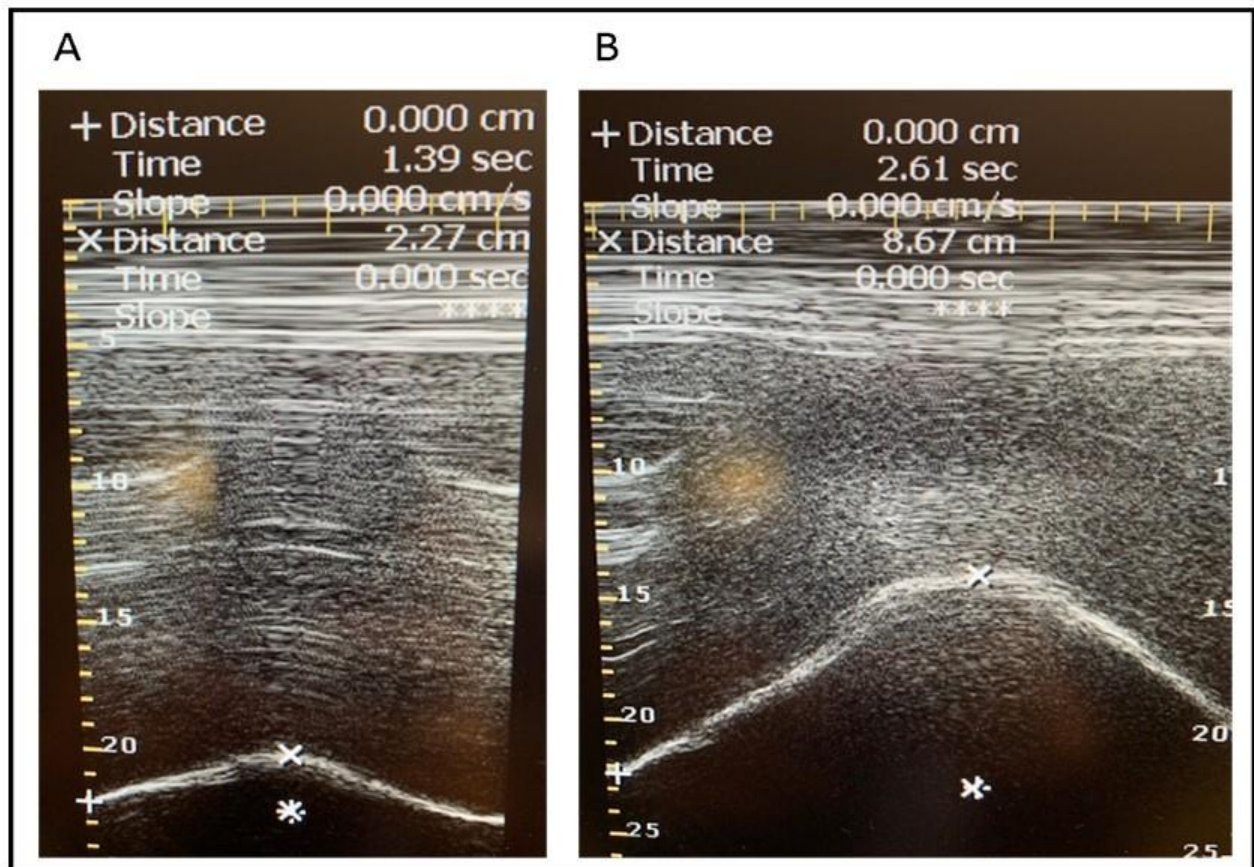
Diaphragmatic function ultrasound assessment during normal (A) and deep breathing (B).
